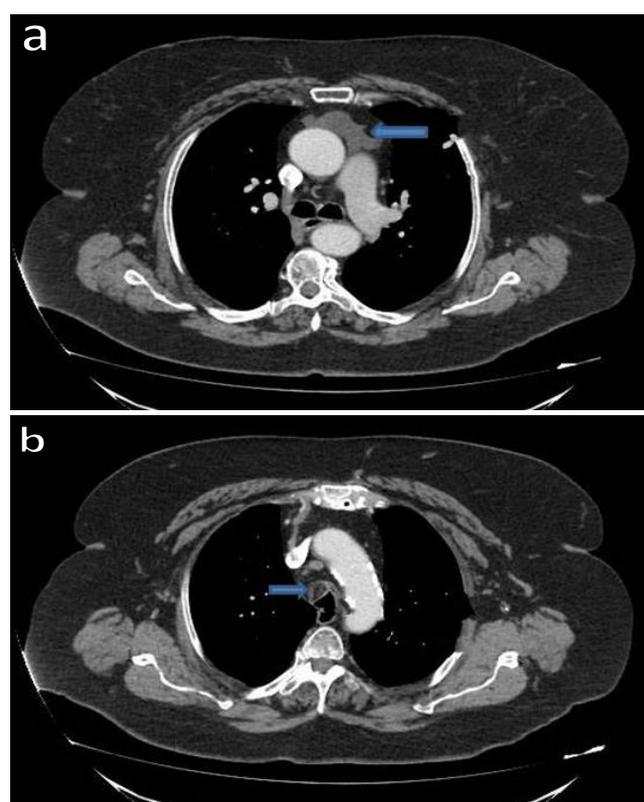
CT view of the mediastinal mass (A), CT view of the tracheal lesion (B)
